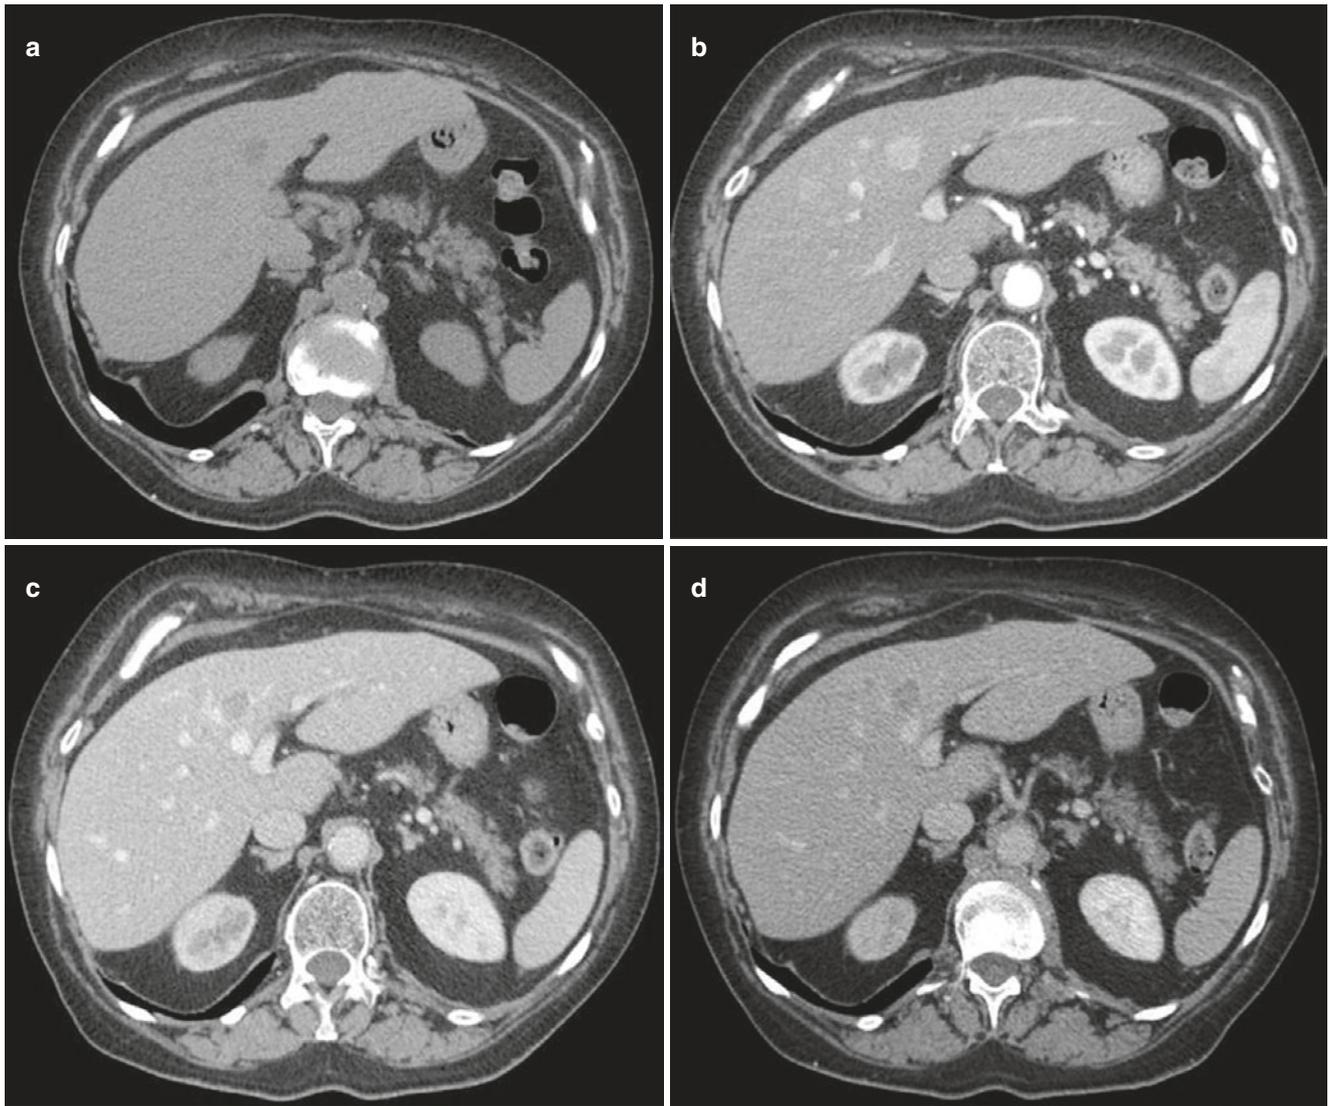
(a–d) Hepatocellular carcinoma in the right hepatic lobe. Unenhanced CT scan (a) shows a 2.5-cm-in-size hypodense lesion in the IV hepatic segment. On late arterial phase (b) the lesion appears
